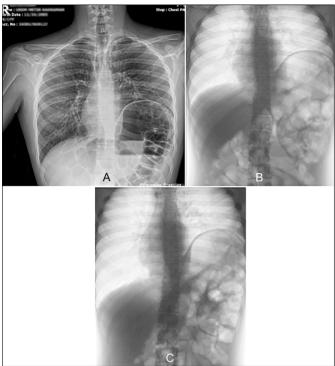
Preoperative imaging. (A) Chest x-ray showing elevated left diaphragm. (B) Fluoroscopy in the expiration phase. (C) Fluoroscopy in the inhalation phase. Please note that while the right diaphragm moves during breathing, the left diaphragm remains stationary.
